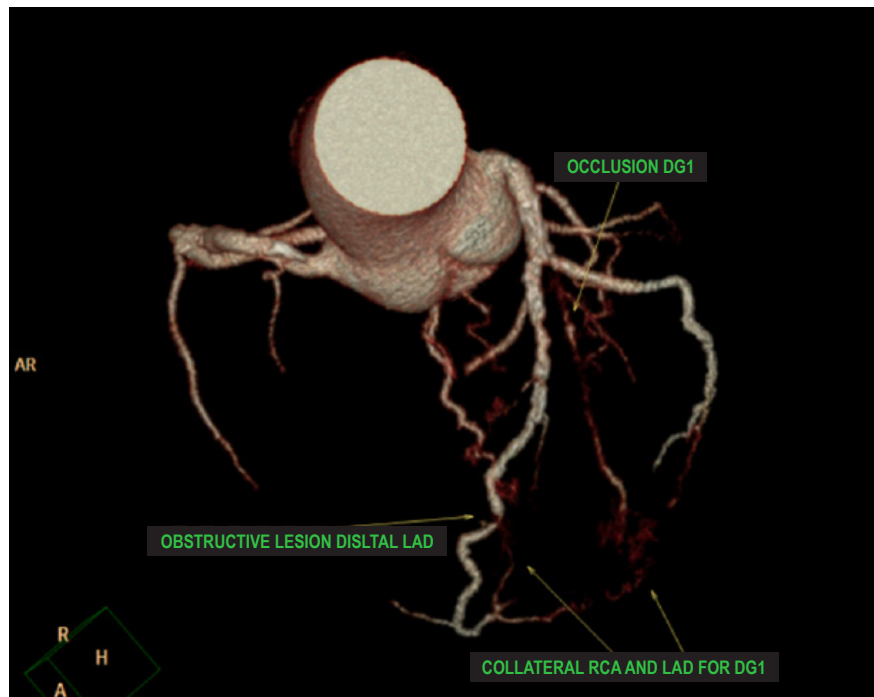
Case 8 - Angio-CT showing significant obstructive alterations and evidence of advanced coronary artery disease. DG1: diagonal 1 coronary artery branch; LAD: left anterior descending artery; RCA: right coronary artery.
